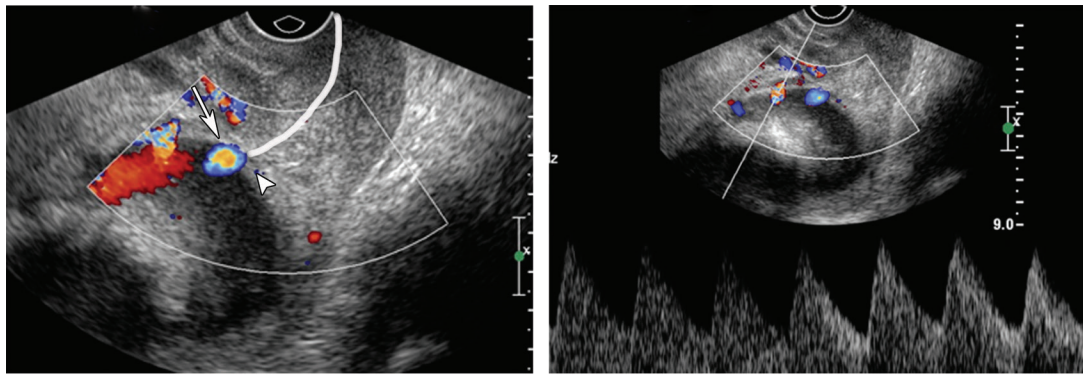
Vasa previa. (a) Longitudinal transvaginal US image at 33 weeks gestation shows fetal blood vessels (arrow) overlying the internal cervical os (arrowhead). Curved white line = cervical canal. (b) Spectral Doppler image shows arterial flow with a fetal heart rate in these vessels, confirming vasa previa.
